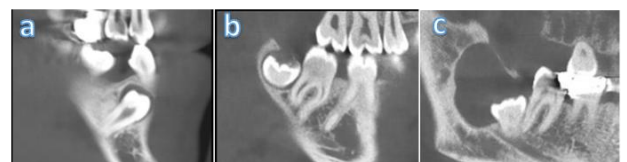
Cone beam computed tomography (CBCT) image showing absent for the gubernacular canal (GC) in unerupted permanent tooth. b. Cone beam computed tomography (CBCT) images showing an example of the present of a gubernacular canal (GC) in an unerupted permanent tooth. c. Cone beam computed tomography (CBCT) images showing an example of an enlarged gubernacular canal (GC) in an unerupted permanent tooth.
